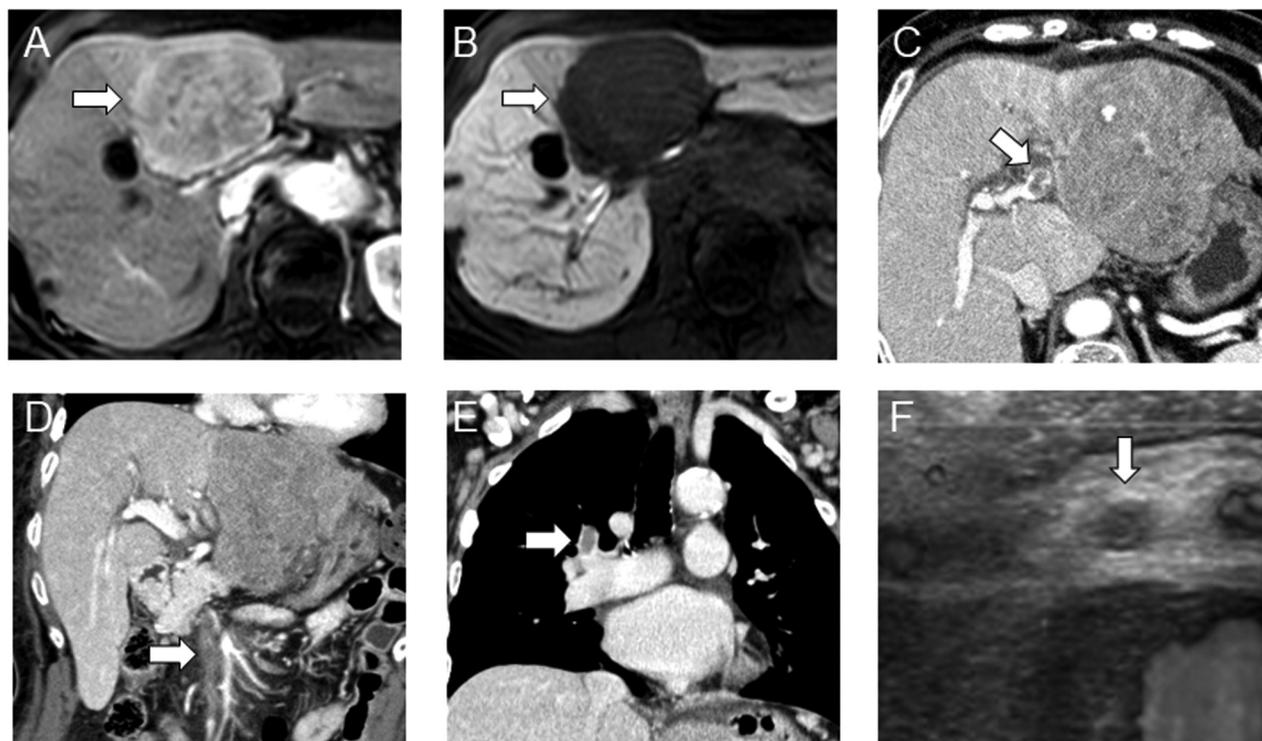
Diagnostic images on admission and intraoperative ultrasound. A: Contrast-enhanced arterial phase T1-weighted magnetic resonance imaging (MRI) displays a hypervascular tumor (arrow). B: Hepatobiliary phase T1-weighted MRI shows a hypointensity tumor (arrow). C: Axial portal venous phase computed tomographic (CT) image shows a washout appearance, with extension to the left first portal branch of portal vein tumor thrombosis (arrow). D: CT of the portal venous phase image, coronal view, shows massive superior mesenteric vein thrombosis (arrow). E: Coronal equilibrium-phase CT image shows a pulmonary embolus affecting the segmental artery of the right upper lobe (arrow). F: Color Doppler ultrasound showed no blood flow through the superior mesenteric vein (arrow).
